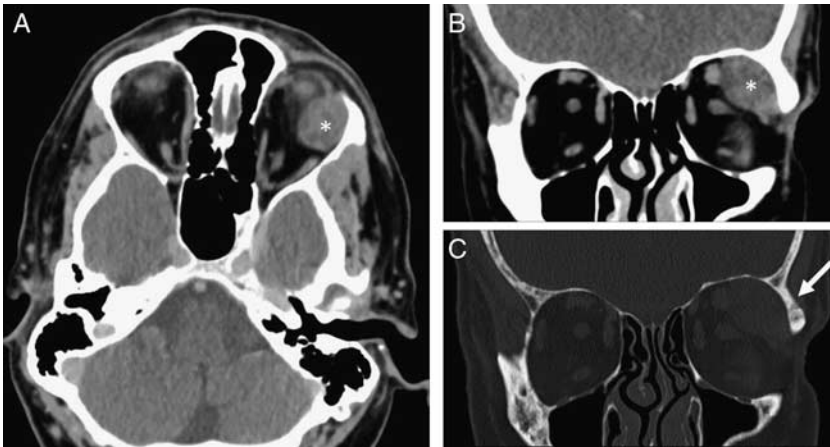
61-year-old man presented with painless left eye fullness and was found to have 4 mm of proptosis on examination. Axial (A) and coronal (B) contrast-enhanced computed tomographic images demonstrate an enhancing soft tissue mass in the left lacrimal gland (white asterisk). Coronal computed tomographic image (C) viewed in bone window settings demonstrates bony thickening and sclerosis of the left lateral orbital wall adjacent to the mass (white arrow).
